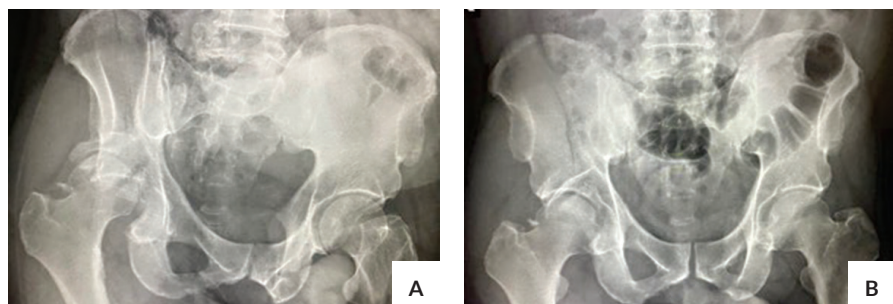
Radiographs from Patient 2 – Male, 49-year-old, car accident. (A) Preoperative, posterior acetabular wall fracture and iliac wing fracture, (B) Preoperative – with traction, (C) Immediate post-operative, (D) 3 months post-operative.
